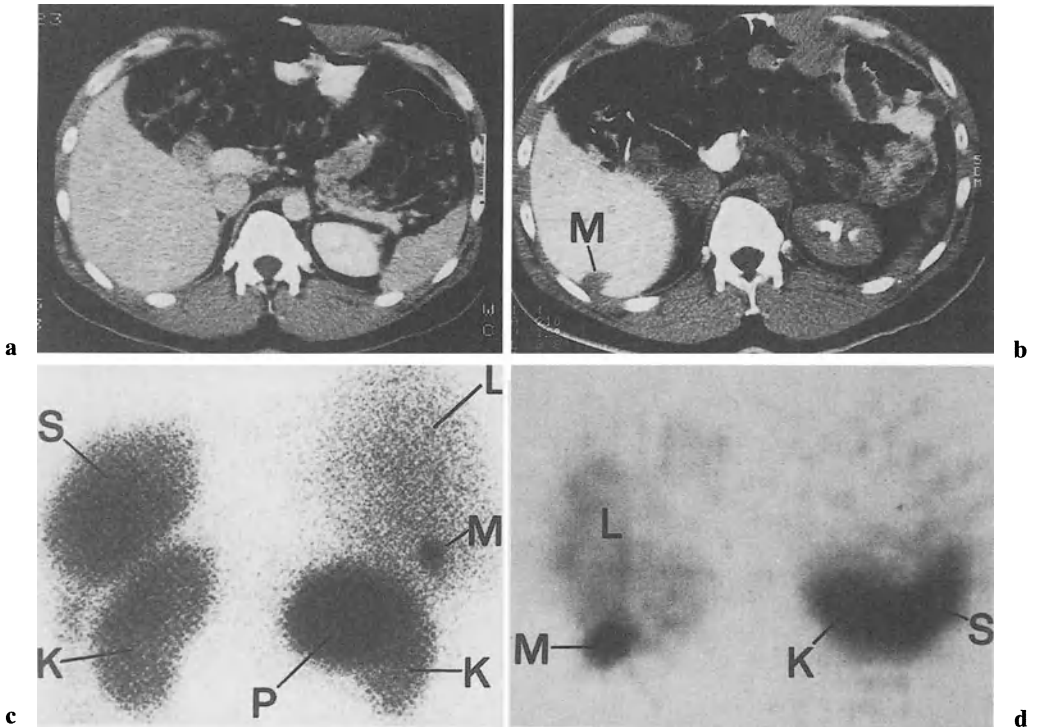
Metastasis (*M*) of a gastrinoma can be clearly seen (c) in the dorsal right caudal liver lobe. *L*, liver; *S*, spleen; *K*, kidney; *P*, primary tumor. This metastasis could also be localized only when 24 months later a spiral computed tomography (CT) was performed (*M* in b). The CT at time of first scintigraphy was negative (a): d Corresponding transversel slice on single photon emission computed tomography which shows metastasis (*M*) exact at the same localization as spiral CT (b)
